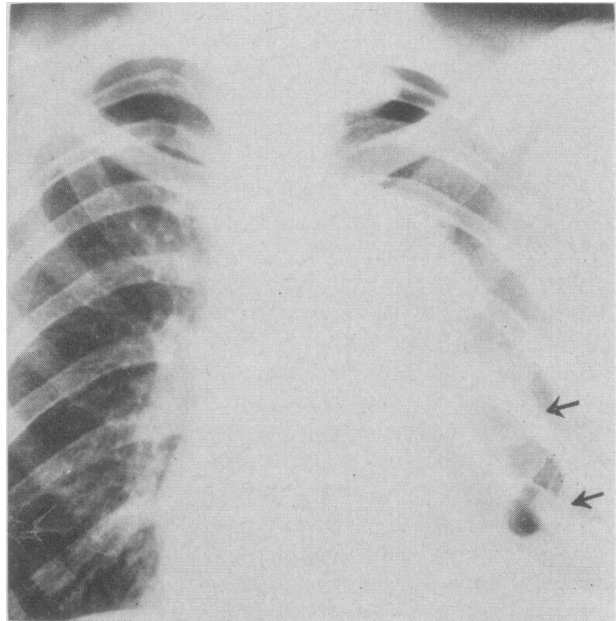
Initial radiograph, before radiotherapy, showing left hilar mass and rounded densities in left lower lung field.
